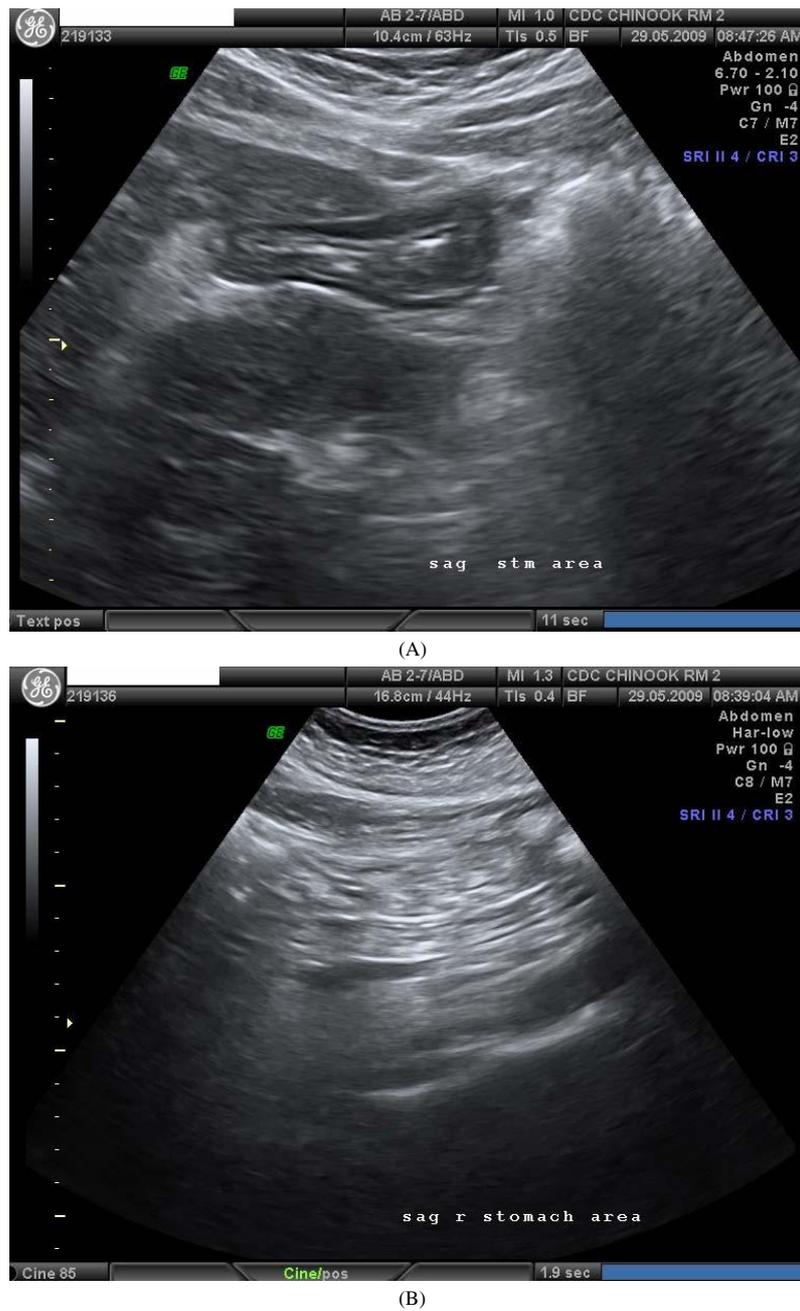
Abdominal ultrasonic images taken 30 days after the end of the therapy revealed the absence of pseudobezoars in the stomachs of both subjects (A and B). The lack of shadowing under the lesser curvature of the stomach is obvious.
